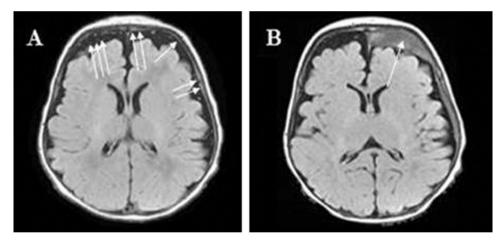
MRI of infant from Rooks et al. with birth-related SDH (A) which developed into a unilateral CSDH at the age 27 days (B). Note the relatively wide subarachnoid space and that the CSDH has filled out a pre-existing space. Reprinted with permission from the American Society of Neuroradiology. MRI, magnetic resonance imaging; SDH, subdural hematoma; CSDH, chronic subdural hematoma.
